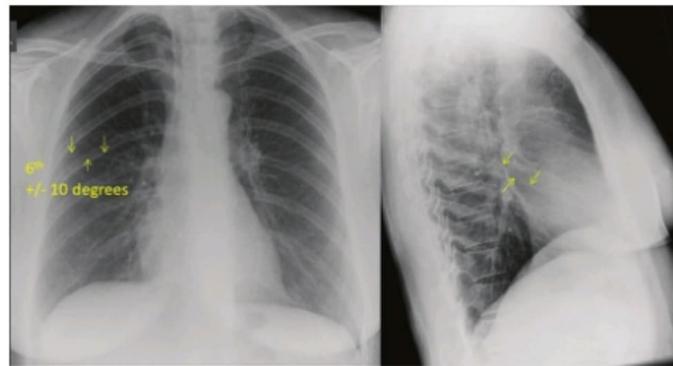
Lung x-ray showing fissures
